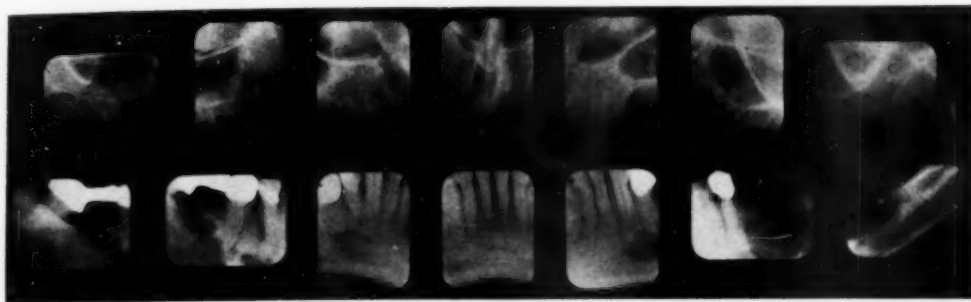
Multiple myeloma. Bilateral involvement of the mandible, with destruction of bone along the inferior border, extending upward into the edentulous spaces. (Reproduced, with permission, from Stafne, E. C.: *Dental Roentgenologic Aspects of Systemic Disease*. J. Am. Dent. A. 40: 265-283, March 1950.)
